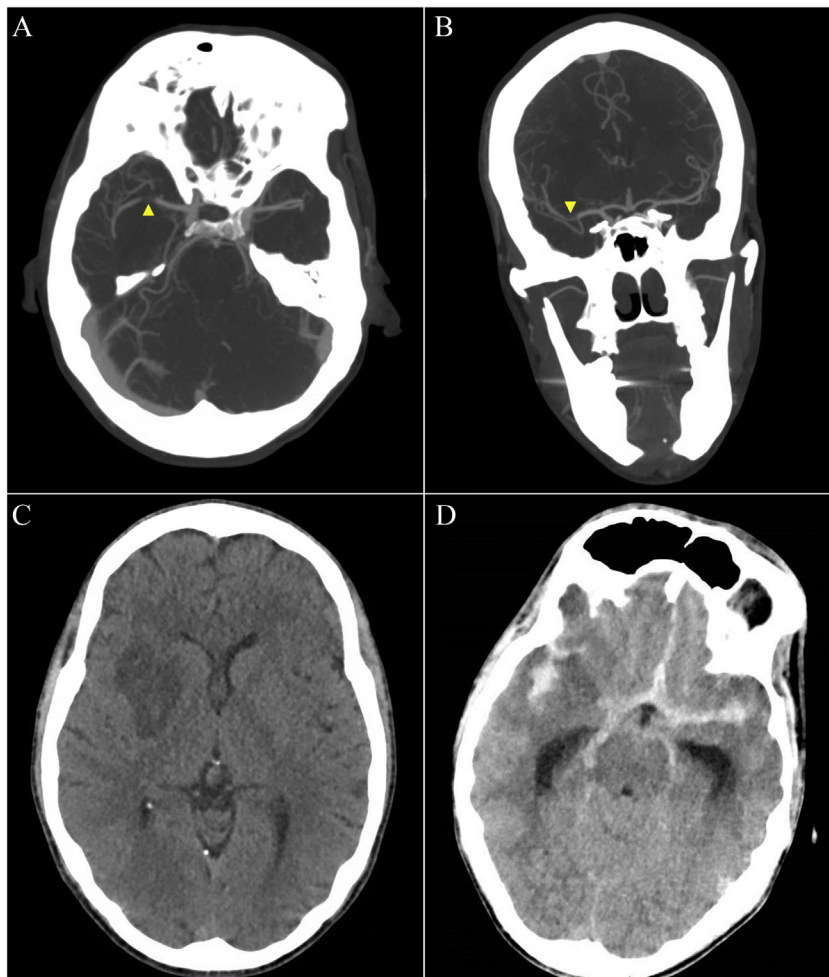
Axial (A) and coronal (B) views of a computed tomography (CT) angiogram on hospital day #1 showing occlusion (arrowheads) in the M2 segment just distal to the middle cerebral artery (MCA) bifurcation. (C) Axial view of a CT of the head on hospital day #2 showing hypodensity within the right basal ganglia and insular cortex, representing an acute infarct. (D) Axial view of a CT of the head on hospital day #3 showing diffuse subarachnoid hemorrhage with intraventricular extension and resulting moderate acute hydrocephalus.
